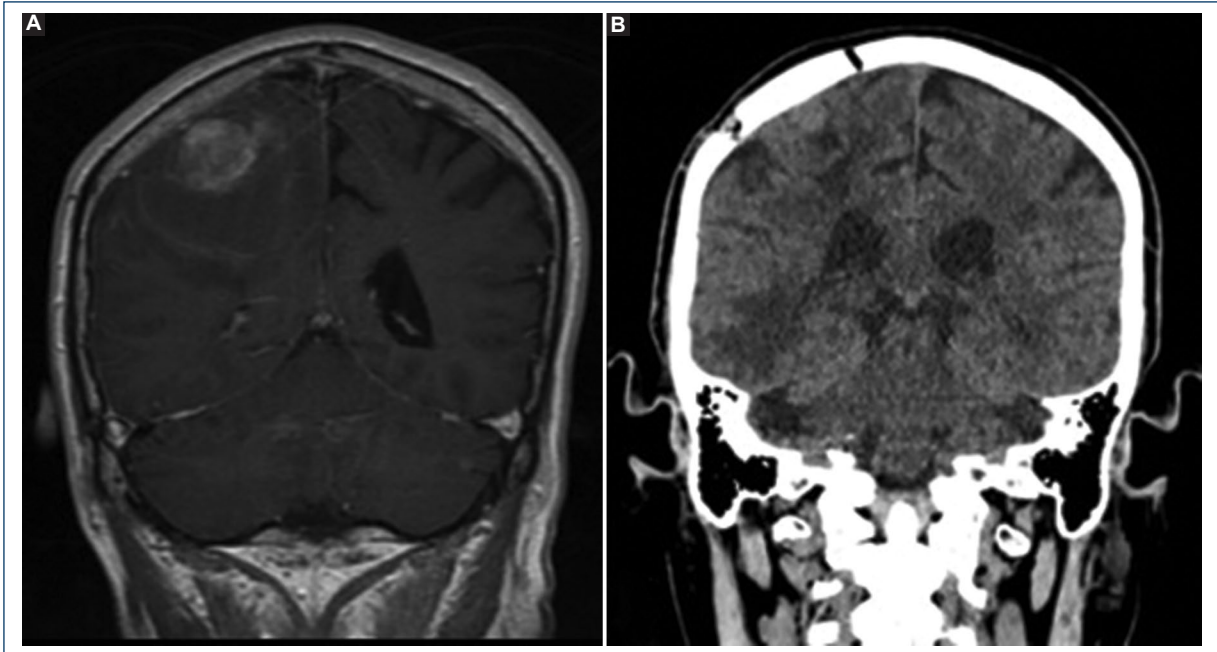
A: pre-operative magnetic resonance imaging in coronal section T1 sequence, right parietal lesion of heterogeneous intensity with ring contrast enhancement. B: simple computed axial tomography in coronal section, right parietal craniotomy, and total resection.
